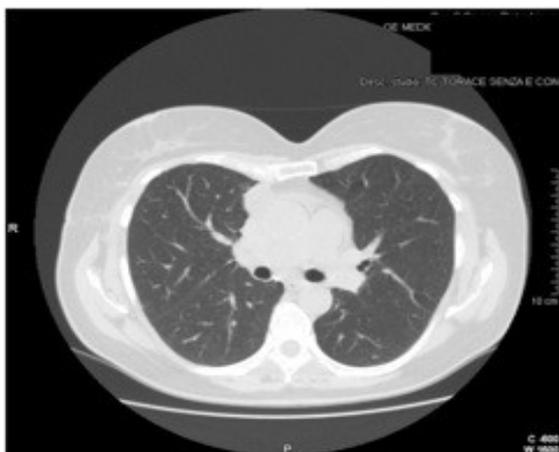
Postoperative CT, three months after surgery, showing a normal lung parenchyma appearance.
